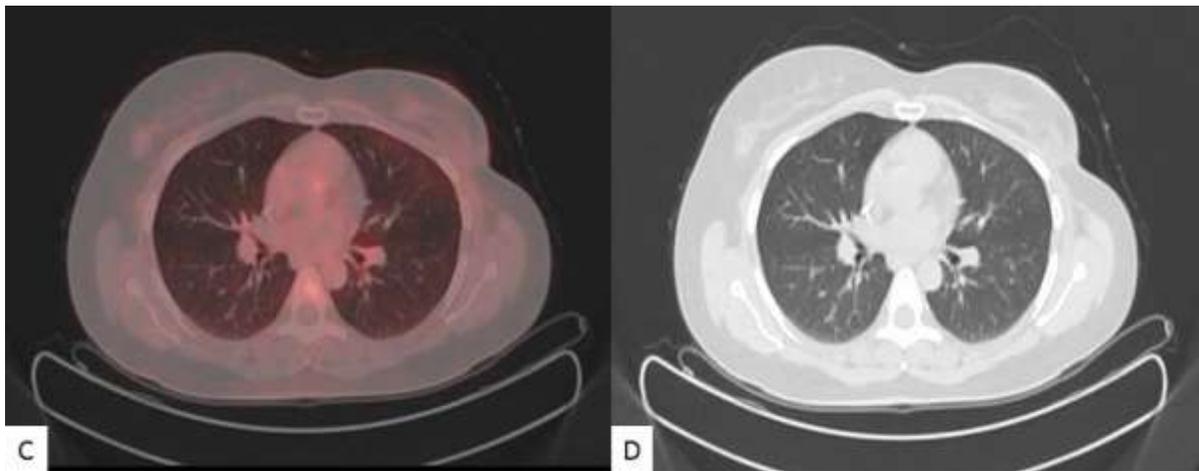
Second FDG PET-CT scan done showed disappearance of the focal (C) uptake in lung and no lesion on CT image (D)
